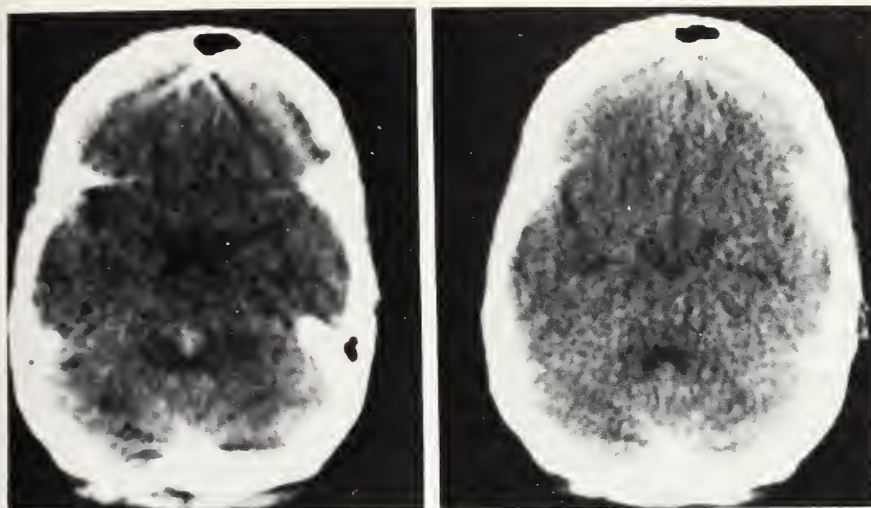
Unenhanced CT of Case 3 showing no extension of blood into the fourth ventricle.
